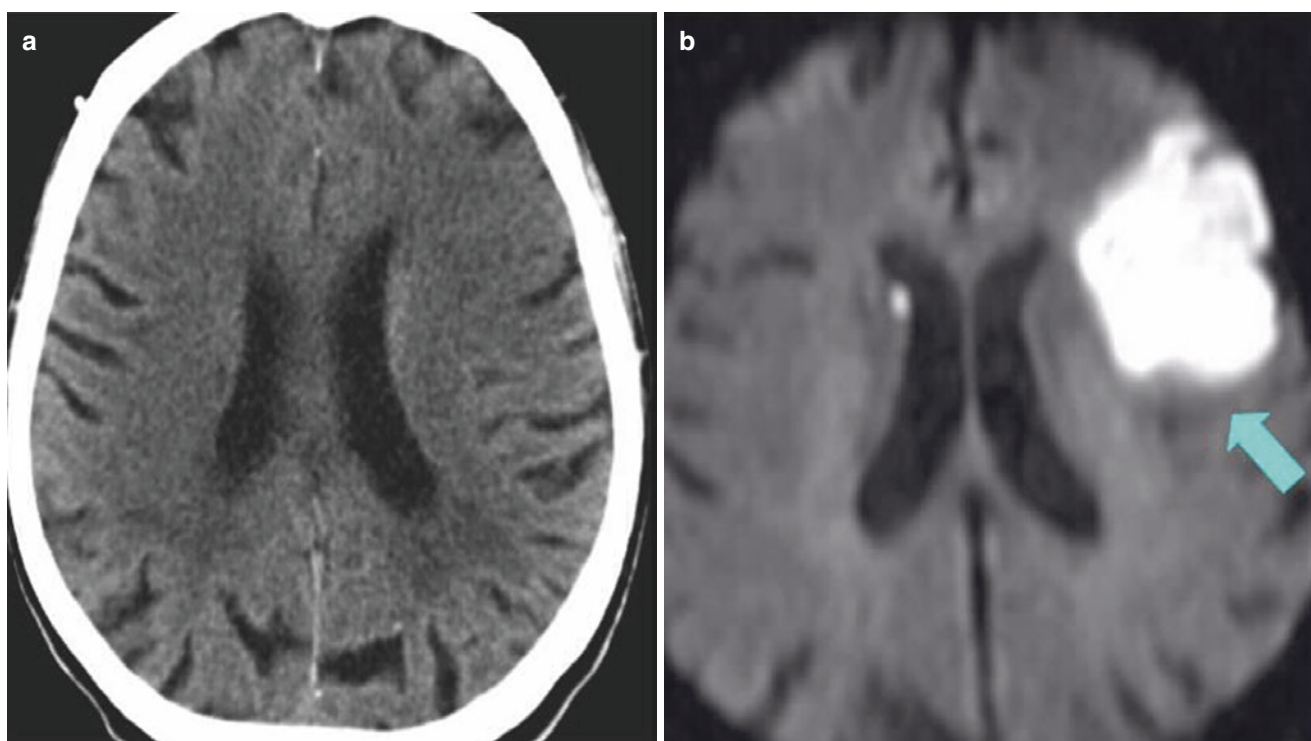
DWI in ischemic stroke: in acute ischemic stroke, the CT scan is often normal (a), but the stroke can easily be seen on DWI (b)
